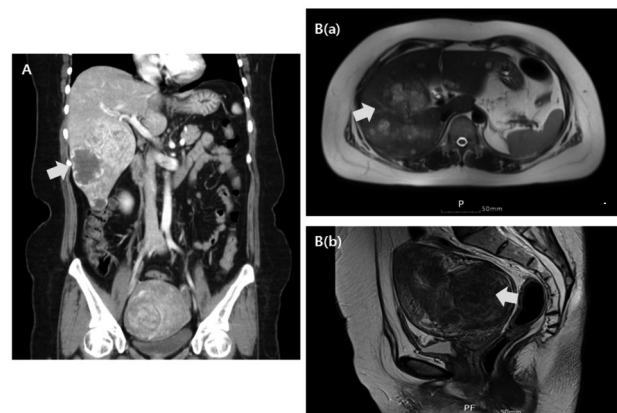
(A) Abdominal CT of the patient, showing a well-defined, lobulated heterogeneous enhancing intrauterine mass, measuring 8.8×6.8 cm, and multiple (> 4), ill-defined, focal infiltrative hepatic masses, measuring < 12×8 cm, with a conglomerated multinodular and focal infiltrative mass at S5 and S6. (B) T2 weighted pelvic MRI of this patient, showing (a) more than four, ill-defined and lobulated contoured high SI hepatic masses throughout the liver measuring less than 12×8 cm, along with conglomerated multinodular and focal infiltrative masses at S5 and S6 and (b) a well-defined, lobulated heterogeneous enhancing intramural mass, measuring 8.9×7.4×7.1 cm, in the right posterolateral wall of the uterine body.
